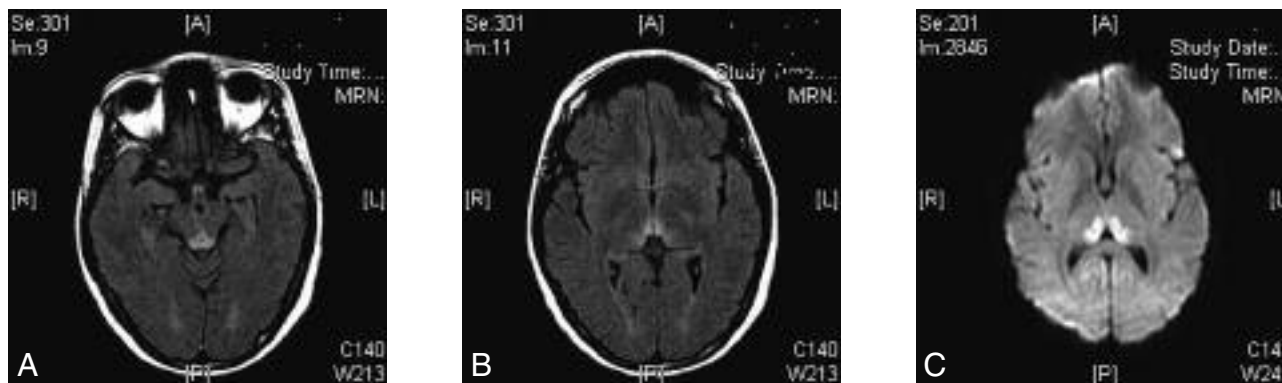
Axial T2 /FLAIR MRI images demonstrating spontaneous hyperintensities in the posterior thalamus, the pons and the periaqueductal grey matter (A and B). Diffusion-weighted axial MRI images showing restricted diffusion in the posterior thalamus (C).
